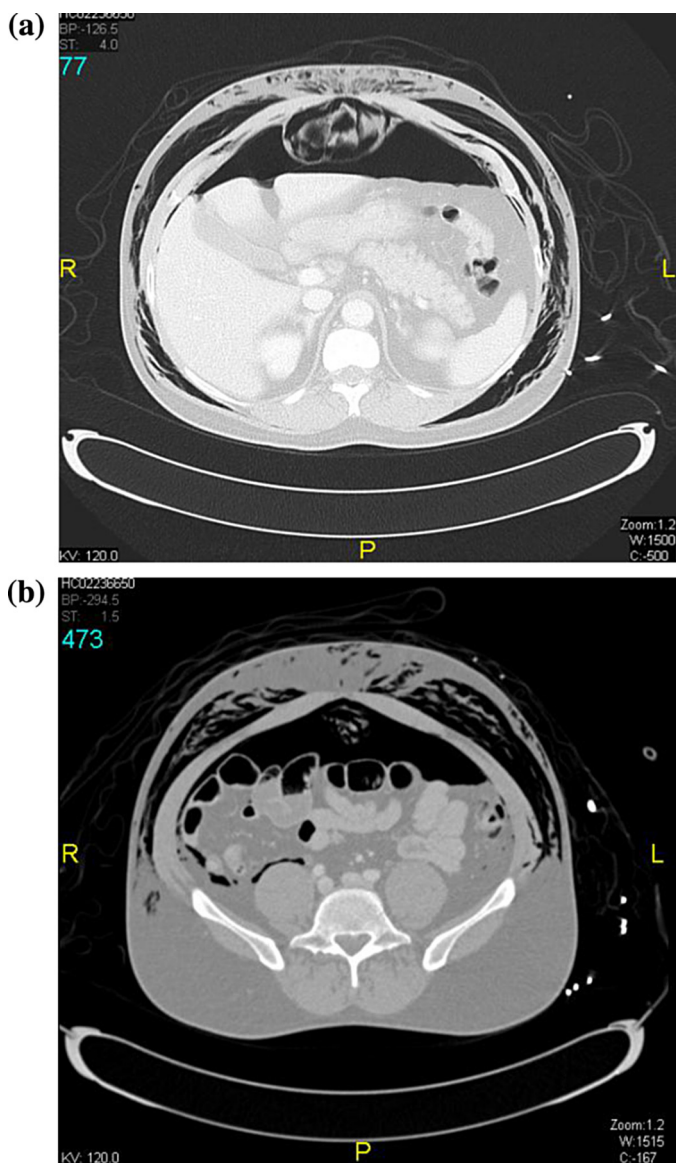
(a, b) CT abdomen showing pneumoperitoneum and surgical emphysema.
